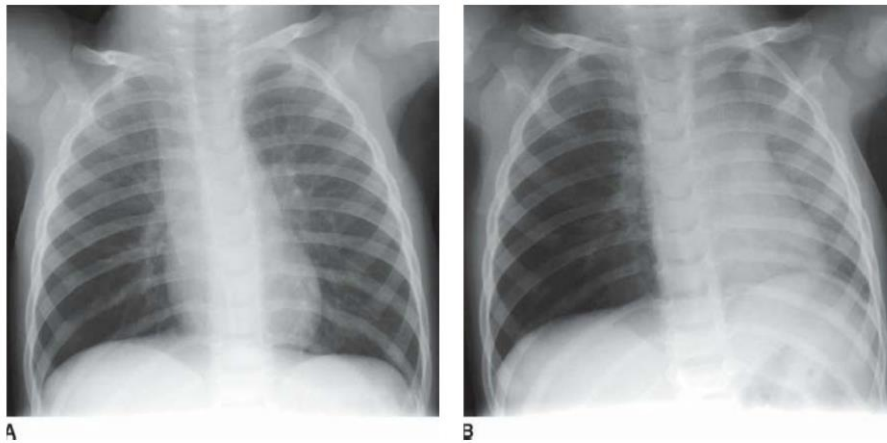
Inspiratory and expiratory radiographs of a child who aspirated a peanut into his right mainstem bronchus. A: Inspiratory view. B: Expiratory view. Note how the right lung remains inflated on expiration. Image courtesy of Dr. C. Branstetter.
